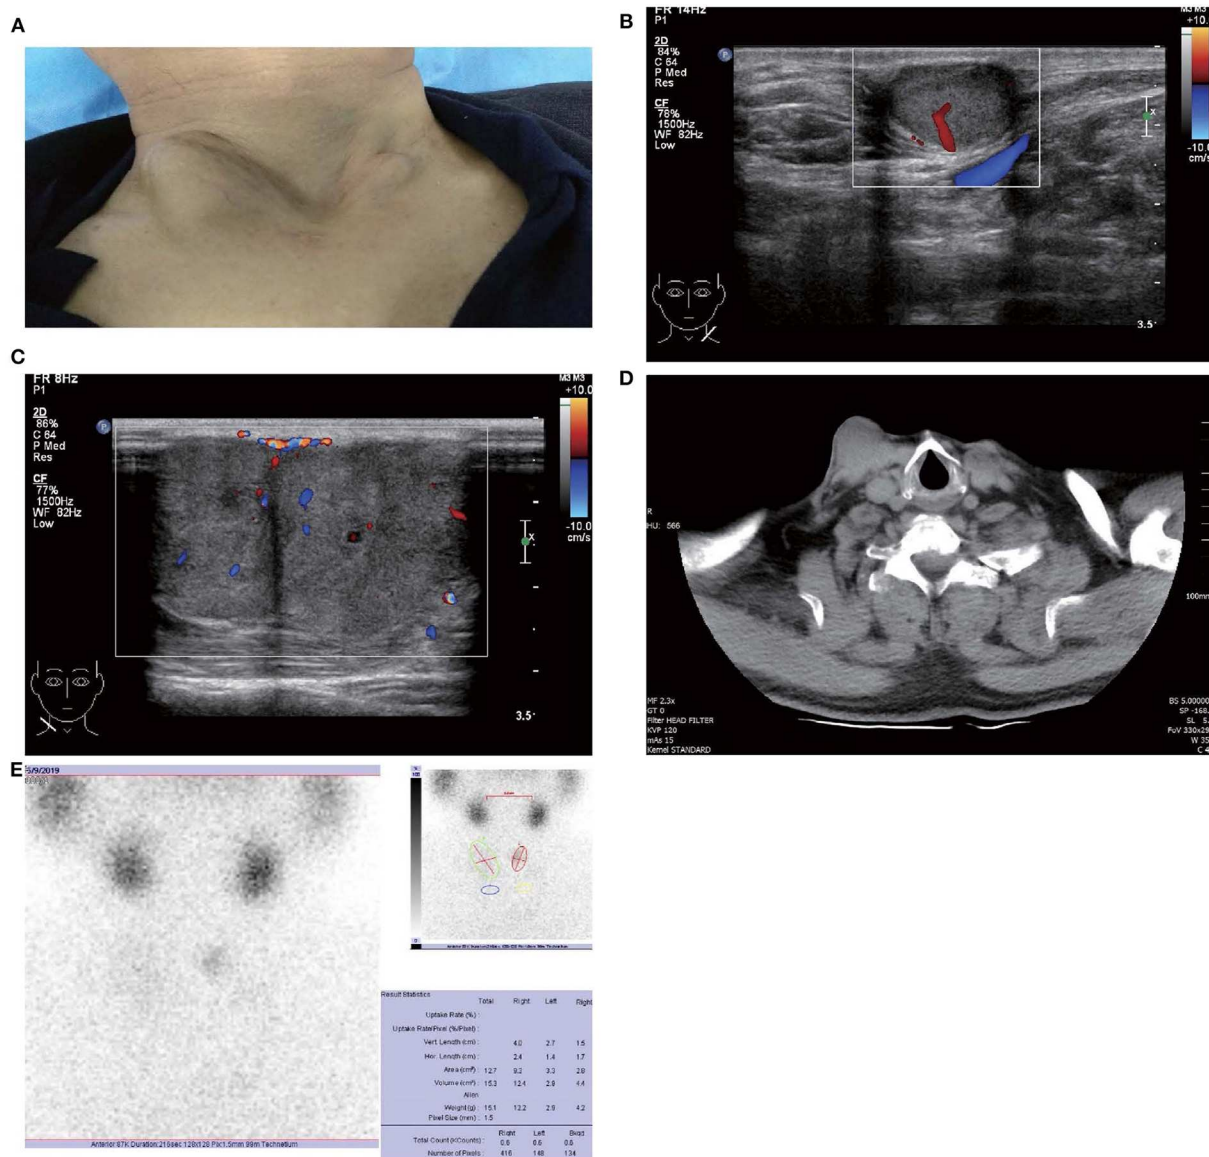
Images of patient and subcutaneous nodules. (A) Multiple subcutaneous soft tissue nodules of metastatic follicular thyroid carcinoma on the anterior neck. (B) Gray-scale ultrasound shows a hypoechoic nodule in the subcutaneous soft tissue of left neck (size were 16 × 11 mm), with wider than taller, well-defined border, irregular margin, perinodular, and intranodular flow and absence of calcification and peripheral halo. (C) Gray-scale ultrasound shows two solid hypoechoic nodules adjacent to each other in the subcutaneous soft tissue of right neck (size of the larger one were 28 × 23 mm), with wider than taller, partially well-defined border, partially regular margin, perinodular and intranodular flow and absence of calcification and peripheral halo. (D) Computed tomography shows several low-density nodules in the subcutaneous of the anterior neck. (E) ^{99m}TcO₄-SPECT reveals a shadow of a cold nodule in the right anterior neck region and a shadow of a nodule in the left anterior neck region.
